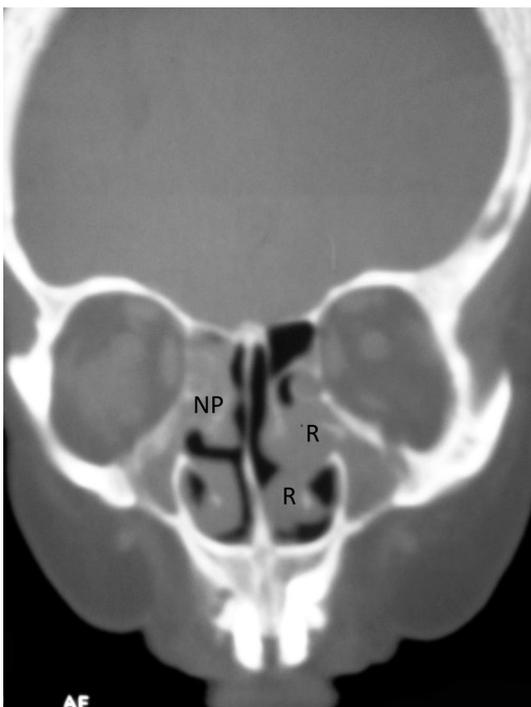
Coronal view of the computed tomography scan. Respiratory epithelial adenomatoid hamartomas (R) is seen in the left nasal cavity. Inflammatory polyps (NP) is seen in the right nasal cavity. The right ethmoid sinuses and bilateral maxillary sinuses are opacified.
